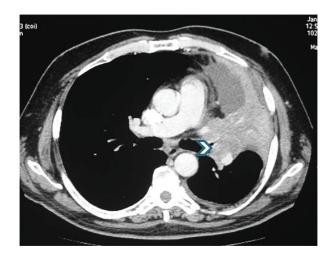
Atelectasis of the left lung in patient with carcinoid tumour. Contrastenhanced CT scan shows endobronchial mass (arrowhead) obstructing left upper lobe bronchus.
